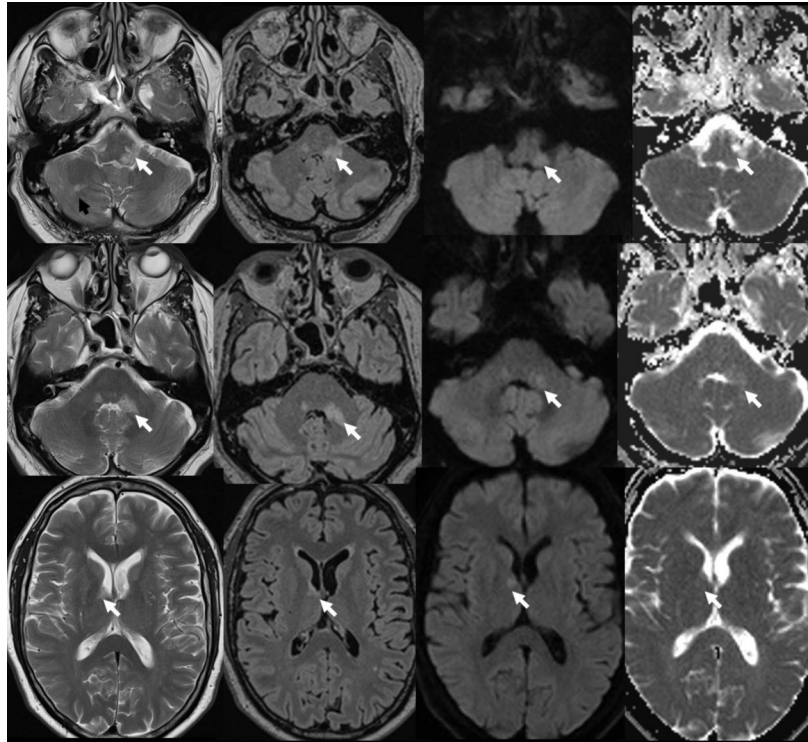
Initial MRI. Signal abnormalities on T2 and FLAIR are noted in pons, inferior cerebellar peduncle on the left side and right anterior thalamus (white arrows) with associated subtle diffusion abnormalities.
